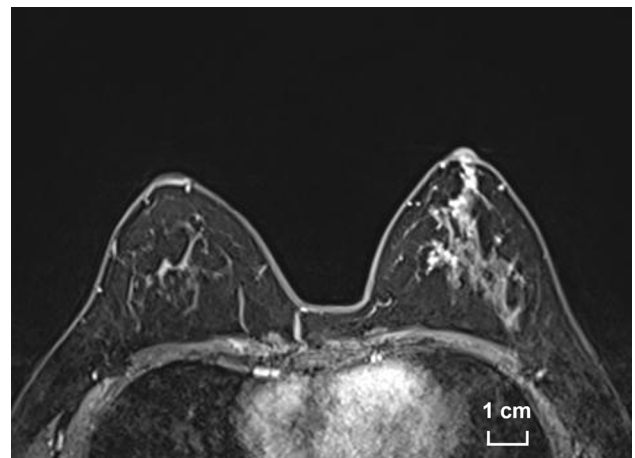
Axial contrast-enhanced magnetic resonance image of the left breast demonstrates dilated ducts with punctate enhancement around
